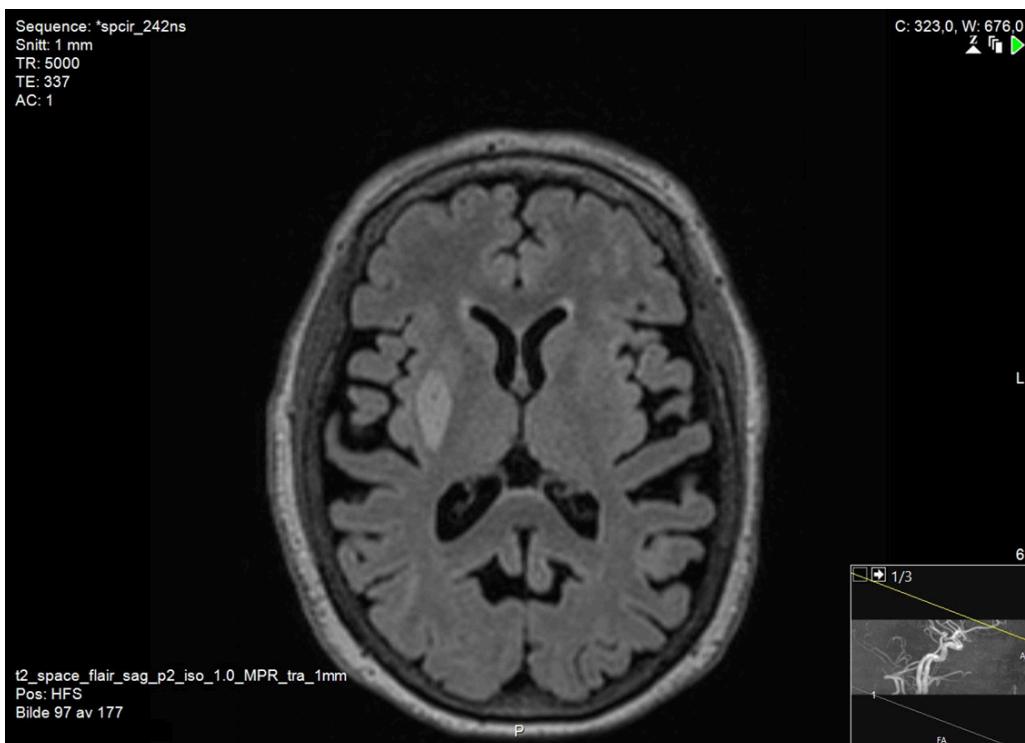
Brain MRI in vascular parkinsonism, subtype 1. T2-FLAIR sequence shows hyperintensity in the right putamen, in this case caused by an acute infarct. Image courtesy of the Department of Radiology and Nuclear Medicine at Oslo University Hospital, Rikshospitalet.
